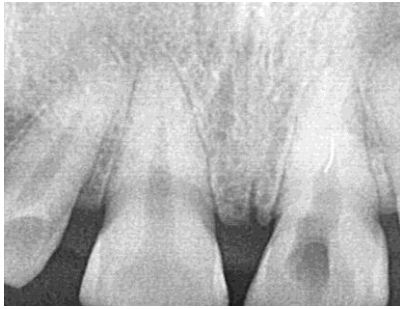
Pre operative radiograph of tooth with fractured file segment.
